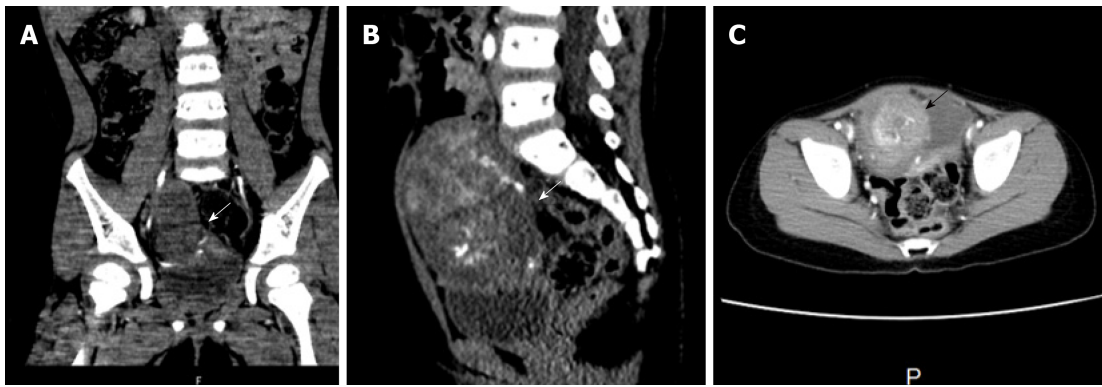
Abdominal computed tomography scan shows a mass (arrows) in the dome of urinary bladder. A: Coronal; B: Sagittal; C: Axial.
